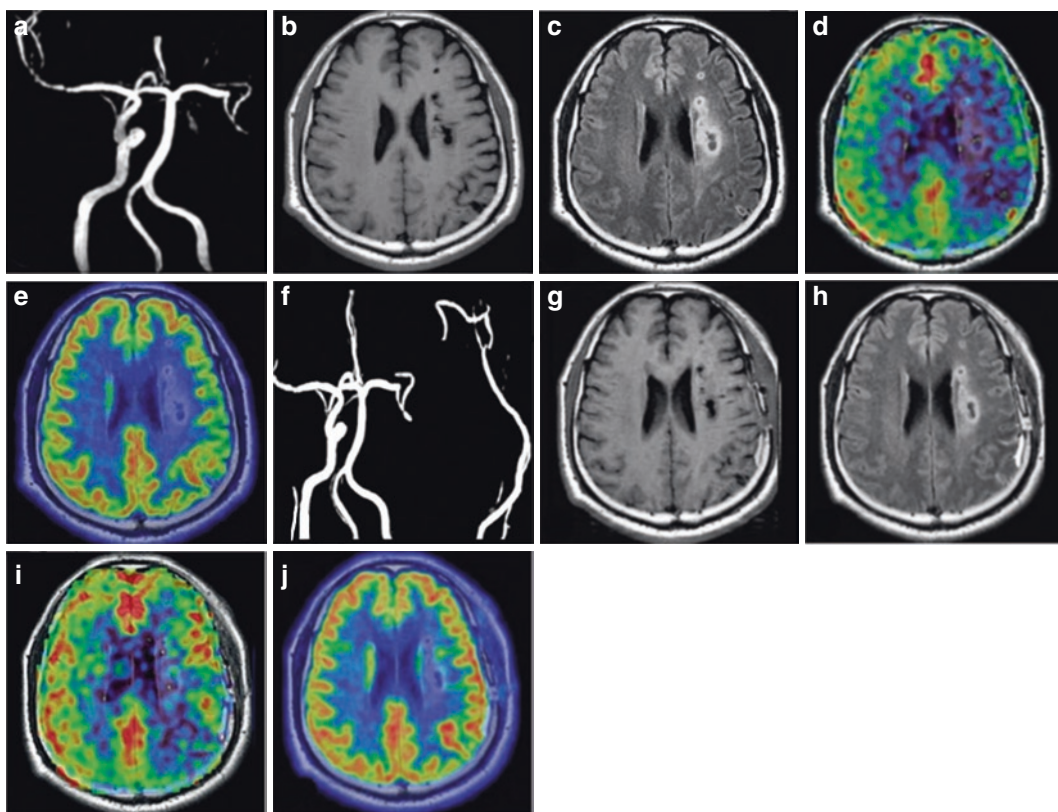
Left internal carotid artery occlusion treated with bypass surgery. A 45-year-old male patient who presented with restricted movement of the right limbs for 7 months. Preoperative images of bypass surgery. MRA shows left carotid artery occlusion (a). MRI shows infarcts in the left corona radiata, manifesting as T₁WI hypointensities (b), and FLAIR hyperintensities (c). Integrated ASL-MRI shows decreased CBF (d), which was approximately 30 mL/(100 g·min). ^{18}F -FDG PET/MR shows
